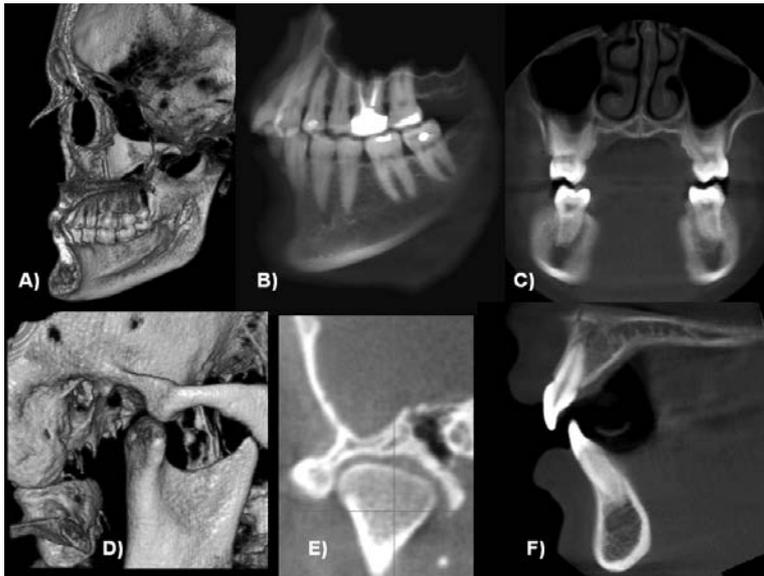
Images taken with a CBCT scanner. A) Surface view of the inside of a subject’s right side; B) Slice view of the dentition, providing a more complete periapical view; C) Coronal view of the molars in occlusion, showing the Curve of Wilson; D) Surface view of the TMJ complex with the mouth opened; E) Slice view of the TMJ complex, showing the condyle; and F) Sagittal view of the overjet in the slice mode.
